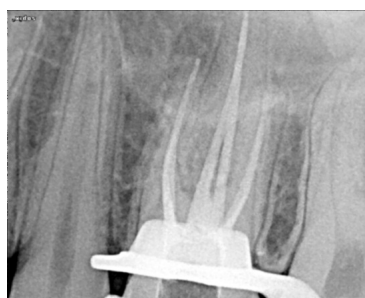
Immediate Obturation Radiograph.
